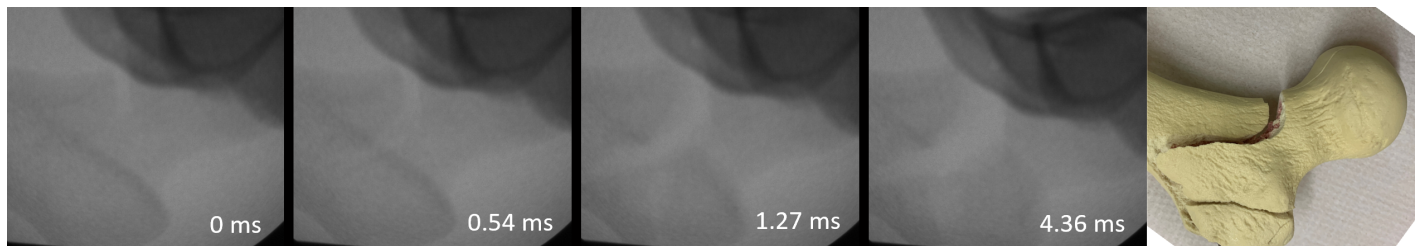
X-ray video frames showing fracture propagation in a sideways fall impact.
